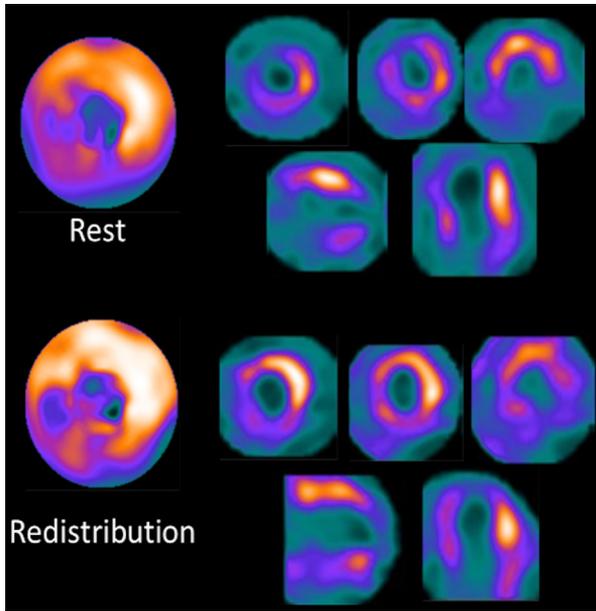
Assessment of myocardial viability by rest-redistribution thallium-201 SPECT. The figure shows 4-hour-redistribution thallium-201 imaging.
